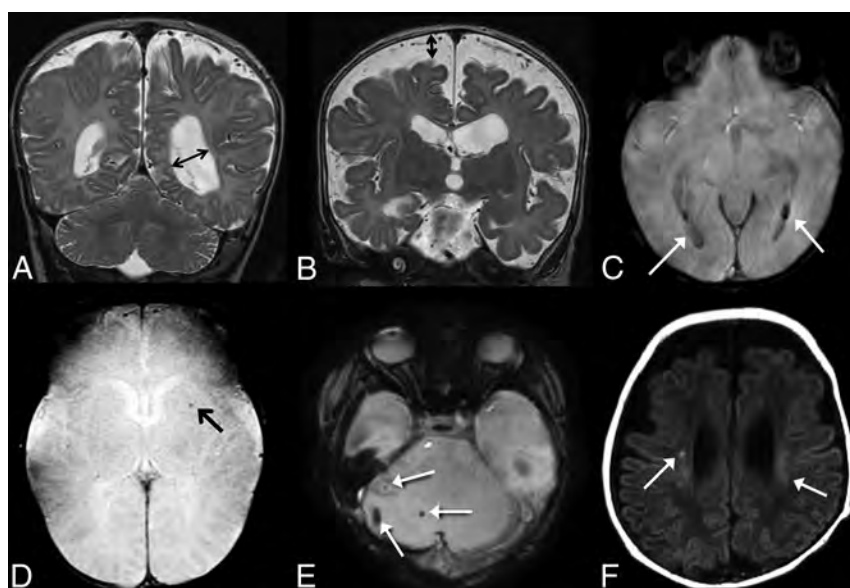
A, Coronal T2-weighted image demonstrates ventriculomegaly, scored as grade 2 on our scale; B, Coronal T2-weighted image demonstrates enlarged extra-axial spaces, scored as grade 2 on our scale. C, SWI shows evidence of grade 2 intraventricular hemorrhage (arrows). D, SWI shows evidence of parenchymal hemorrhage, grade 1 on our scale (arrow). E, SWI shows foci of cerebellar hemorrhage, grade 2 on our scale (arrows). F, Axial T1 weighted images demonstrate foci of bilateral white matter injury, grade 2 on our scale (arrows).
